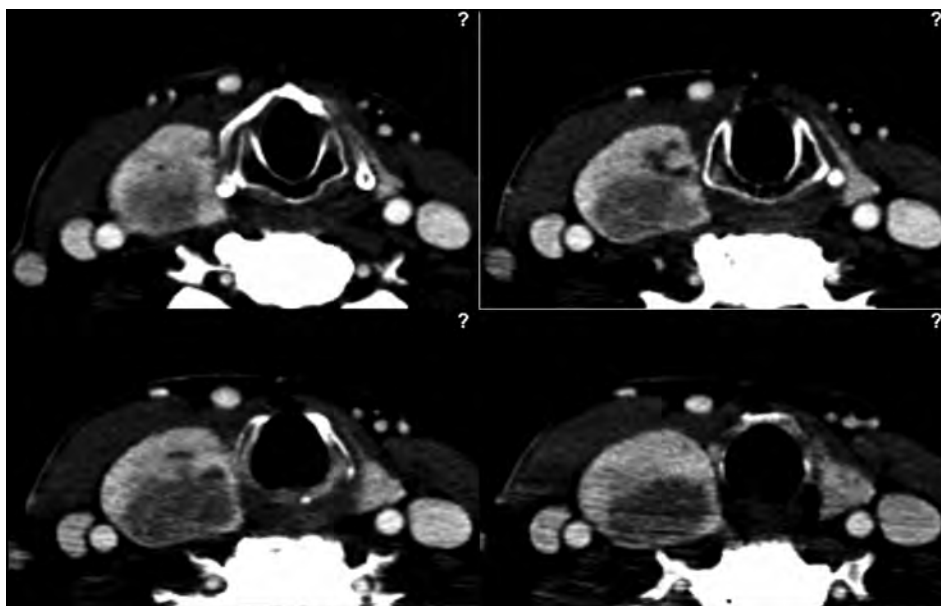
Preoperative CT scan of the neck.
